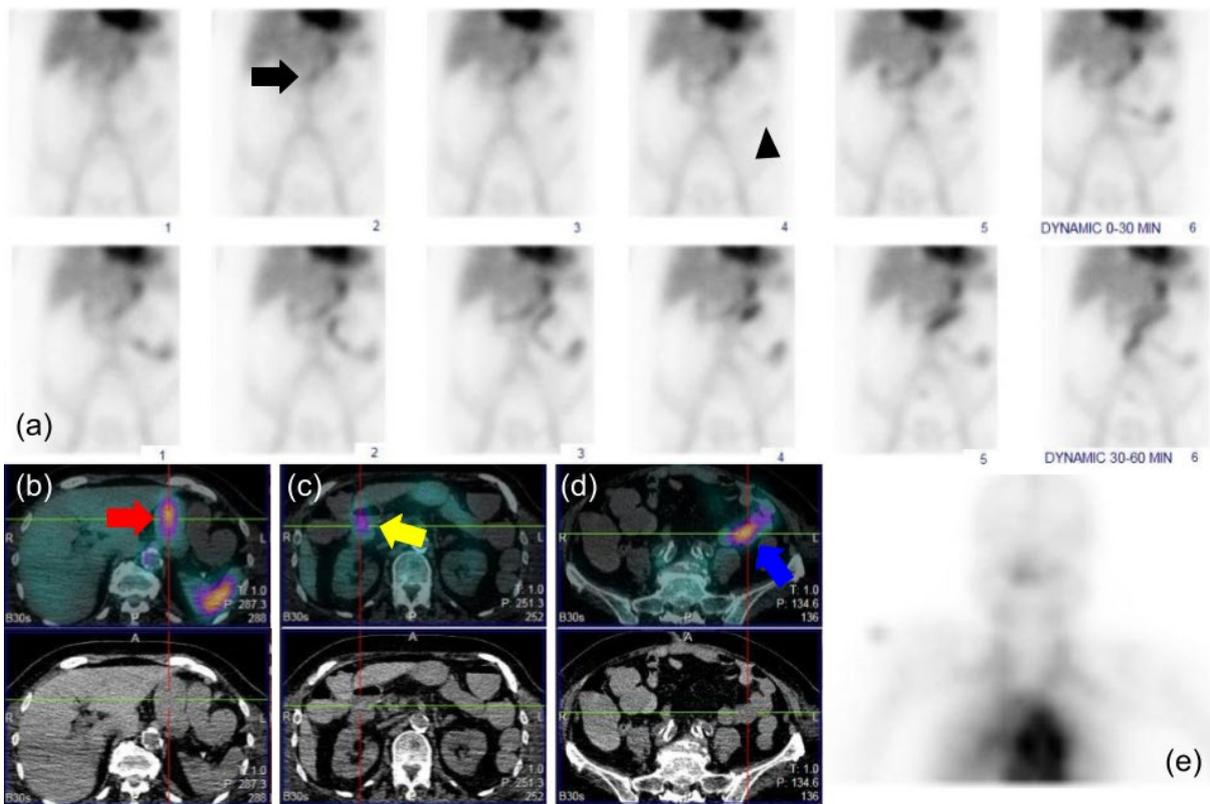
(a) Gastrointestinal bleeding scintigraphy dynamic imaging sequence (5 min/frame) show a focus of increased tracer uptake in the mid-abdomen (arrow) at the 10th minute of the study, increasing in intensity, with antegrade movement towards the left lower quadrant seen by the 20th minute (arrowhead). (b) (c) (d) Fused SPECT/CT images localize the bleeding sites to the stomach (red arrow), duodenum (yellow arrow) and the proximal jejunal (blue arrow) segments. (e) Anterior static image of the neck shows no tracer uptake in the thyroid and salivary glands to denote the presence of free pertechnetate.
